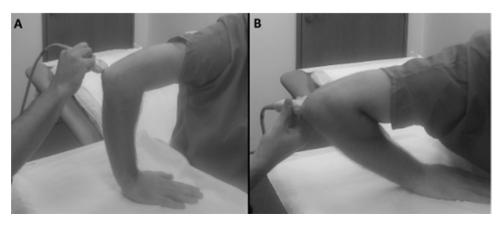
Ultrasound technique. A: Static exploration of the ulnar nerve and it surrounding structures. Patients were in the seated position with the palm of their hand placed either on their knee or on a table. The elbow was flexed to 90° in the direction of the radiologist, with the shoulder adducted and internally rotated by approximately 30°. B: Dynamic exploration of the ulnar nerve during flexion of the elbow.
